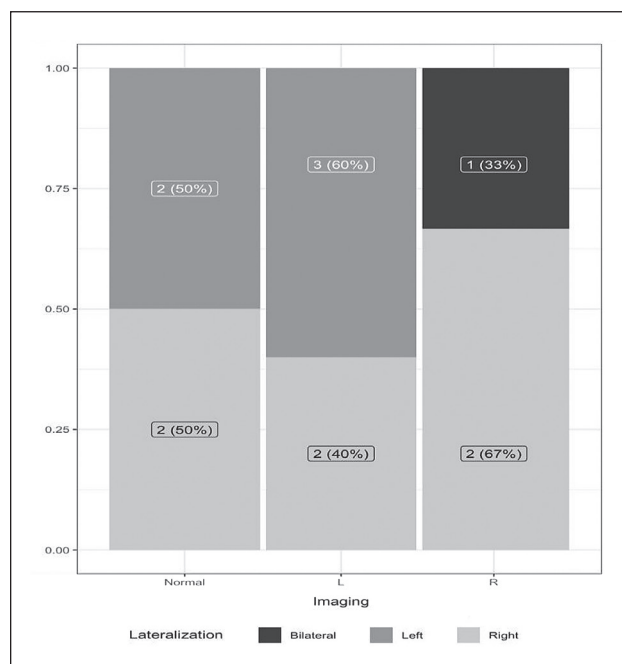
Agreement between adrenal vein sampling (AVS) and CT findings depicted with a width-stacked column chart.
